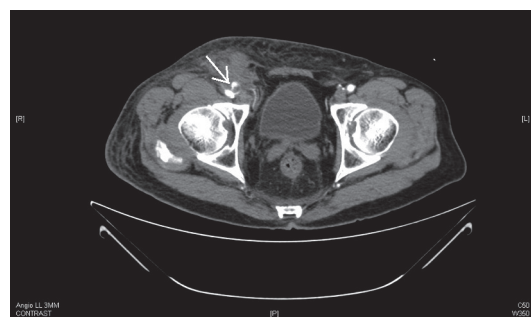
Computed tomography (CT) angiogram of the right lower limb. Arrow: right groin focal arterial blush adjacent to the common femoral artery.
